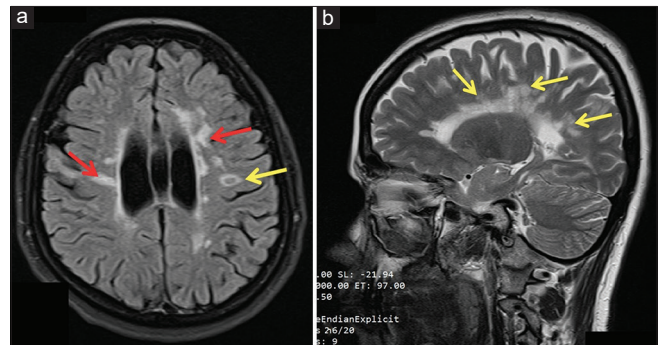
(a) MRI brain (T2 coronal) showing hyperdense white matter lesions perpendicular to the body of lateral ventricle (red arrow) and central hypodense with rim of hyperdense lesion indicating chronicity of MS (yellow arrow); (b) MRI brain (T2 sagittal) of patient 4 showing periventricular white matter lesions perpendicular to the body of the lateral ventricle (yellow arrow)
